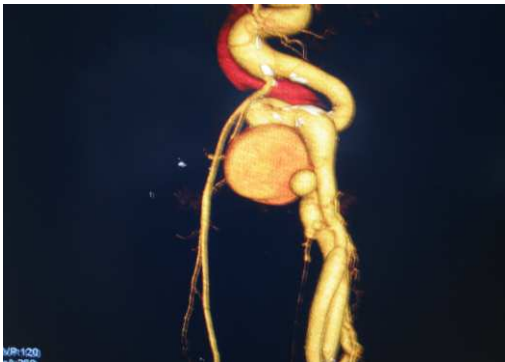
3D reconstructed CT Angiogram showing the AV fistula and abnormally dilated proximal veins.
